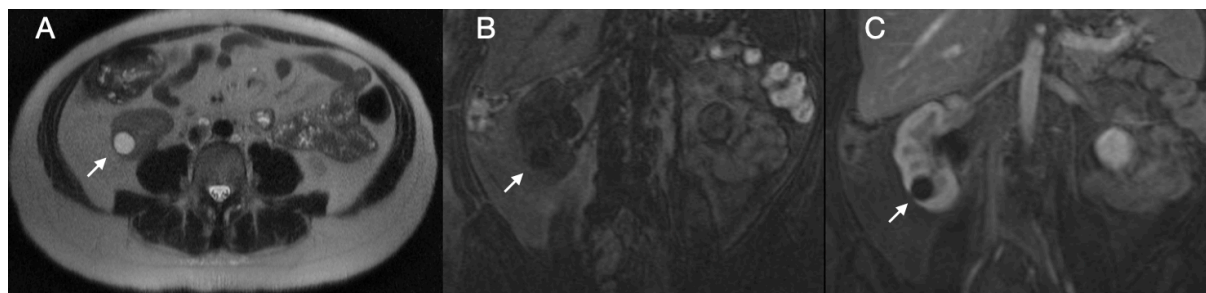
A) T2WI haste axial MR image of a male patient of the right kidney shows a simple type I renal cyst. B) Coronal T1WI FL3D FS non-contrast-enhanced MR image of the same patient shows apparently normal kidneys with evidence of the same renal cyst on the right side. C) Coronal T1WI FL3D FS Contrast-Enhanced MR image at the same level shows no enhancement of the cystic lesion of the right kidney.
